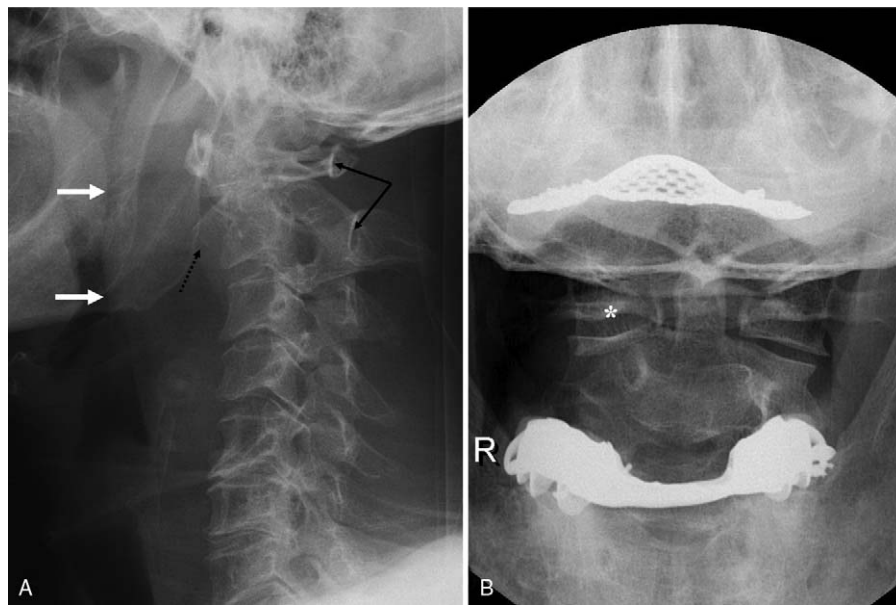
Plain radiographs of cervical spine showed extensive soft tissue swelling (white arrows), a fracture fragment (dark dotted arrow), disruption of spinolaminar line at C1–2 level (dark arrows) (A), and bony overlapping of right side lateral joint of C1–2 (asterisk) (B).
